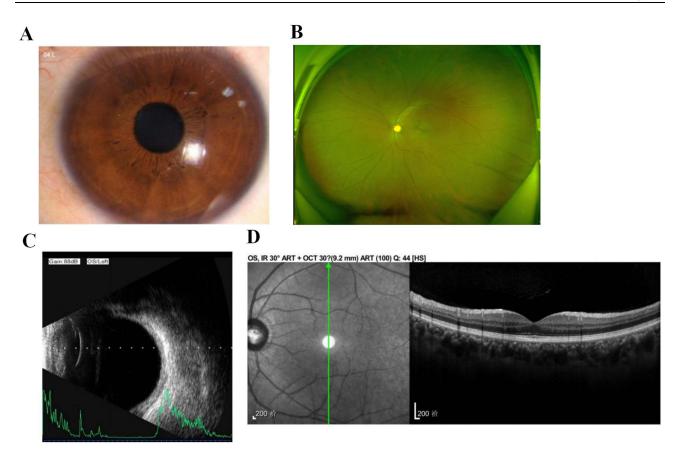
Images of the anterior segment (A), fundoscopy (B), B-ultrasound examination (C), and optical coherence tomography (D) of the left eye, showing no significant abnormality.
